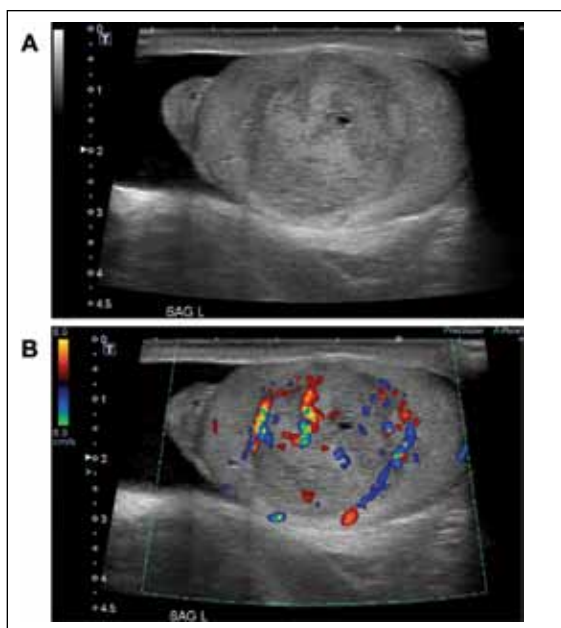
A: Ultrasonography of the left testicle depicts a well-circumscribed hypoechoic nodule measuring 2.8 cm in maximum diameter. B: Colour Doppler interrogation demonstrated hypervascularity.
